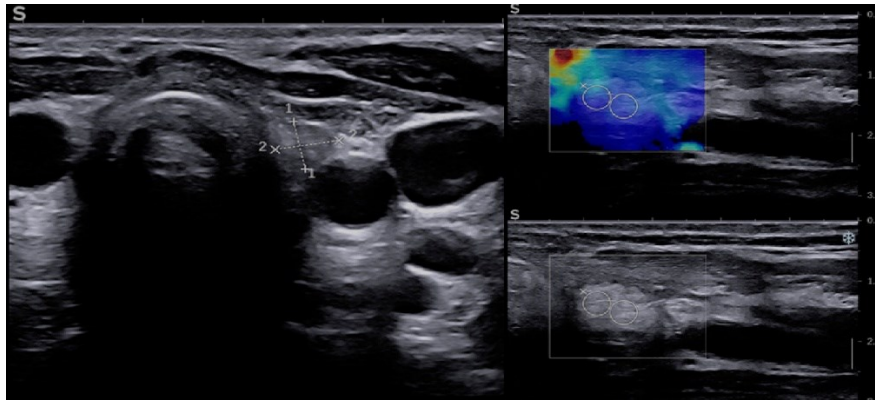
cervical ultrasound showing residual thyroid tissue with involution, no nodules, soft appearance in SWE.
